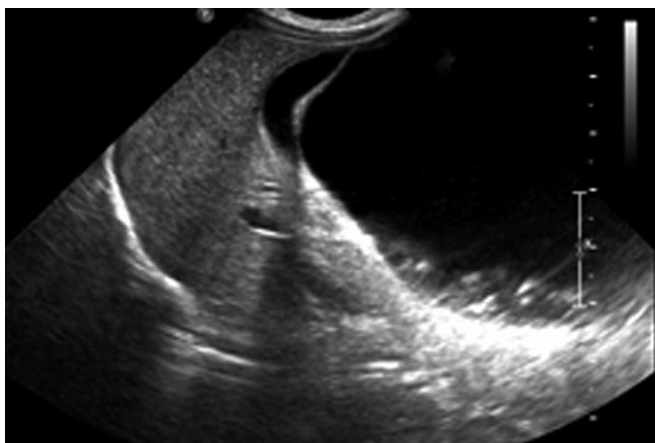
Postnatal Ultrasound (2 months): enlarged intra-abdominal cystic lesion of unknown origin measuring 10cm.
